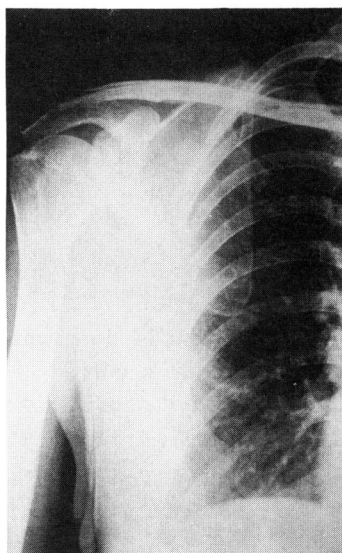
Anteroposterior radiograph of the right shoulder, showing downward rotation of the scapula when the arm at the side.
